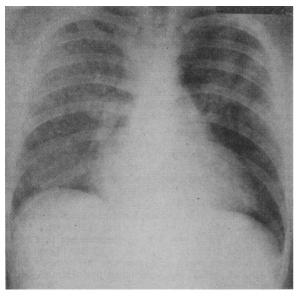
Case 3. Radiograph taken on admission, 26 January 1963.
